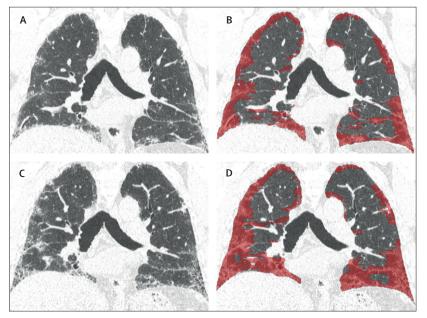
Sequential quantitative CT fibrosis measurement in a patient with idiopathic pulmonary fibrosis (A) Baseline coronal image and (B) regions of fibrosis (red) classified by data-driven texture analysis on baseline CT. (C) Coronal image from 14 month follow up CT and (D) regions of fibrosis (red) classified by data-driven texture analysis at follow-up. The extent of fibrosis increased from 39% to 52%, and the patient deteriorated physiologically, with decrease in forced vital capacity from 66% predicted to 45%.
